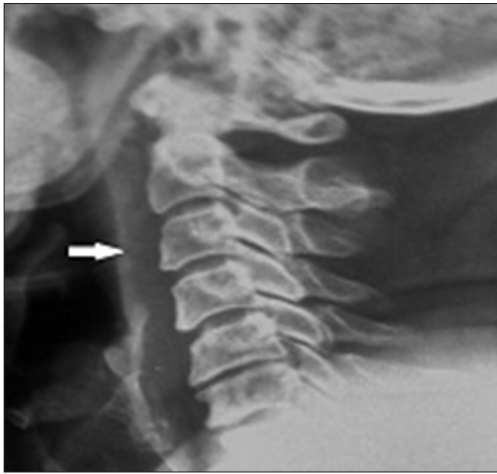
50 year old male with acute longus colli calcific tendinitis. Lateral radiograph of cervical spine shows increased prevertebral soft tissue thickness (arrow)
